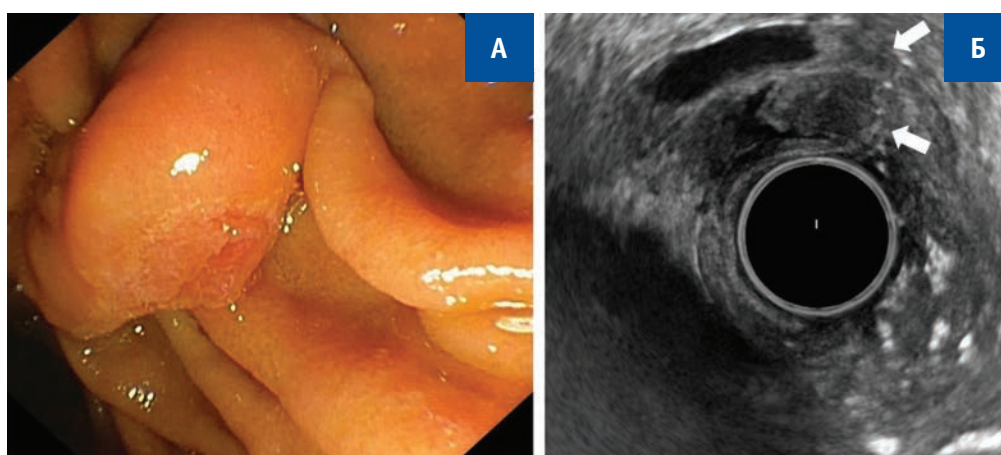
A — duodenoscopy: MDP adenoma is exclusively intraductal in nature without the presence of an extrapapillary component; B — endosonography: intraductal adenoma spreading to the walls of the MPD and CBD simultaneously (arrows)
